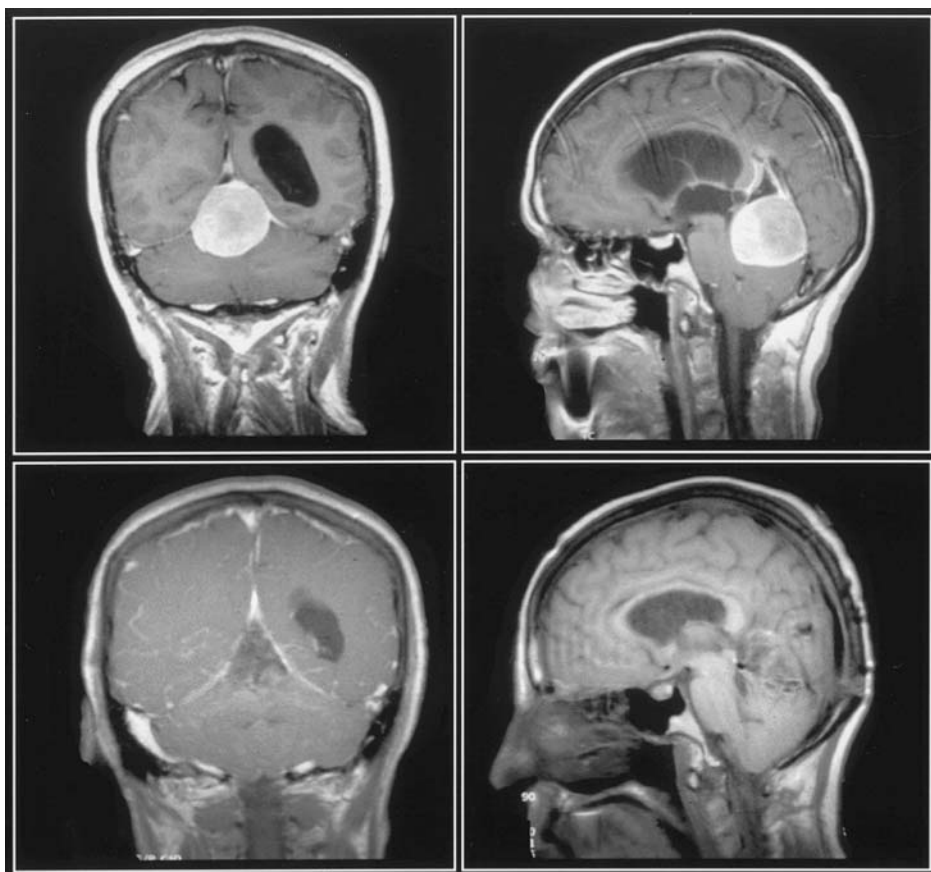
Coronal and sagittal gadolinium-enhanced T1-weighted MR images of a 55-year-old female patient who presented with headache and unsteady gait (upper left and upper right). Because of the small posterior fossa and the near-vertical tentorial angle noted on the sagittal MRI (upper right), the tumor was approached via the occipital interhemispheric/transtentorial route with the patient in the prone position. Following total resection (lower left and lower right), her presenting symptoms resolved completely.
